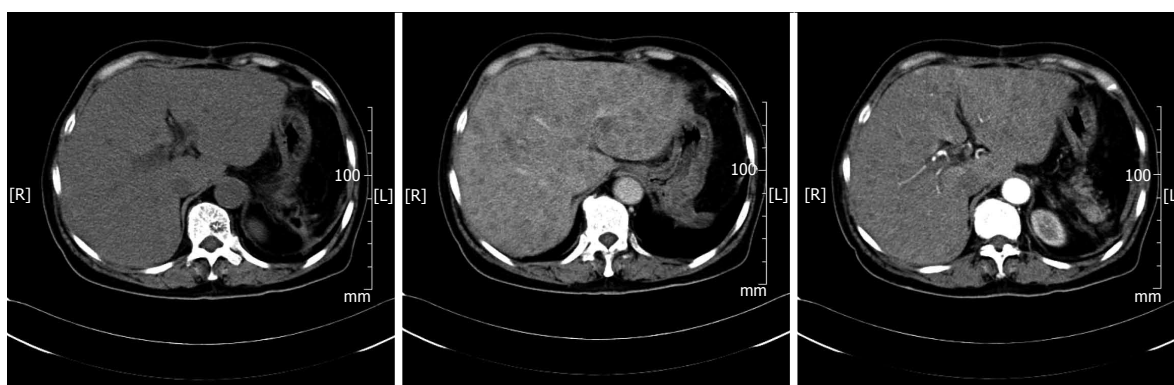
Contrast-enhanced computed tomography images showing hepatomegaly and multiple liver nodules with slight reinforcement and spleen loss.
